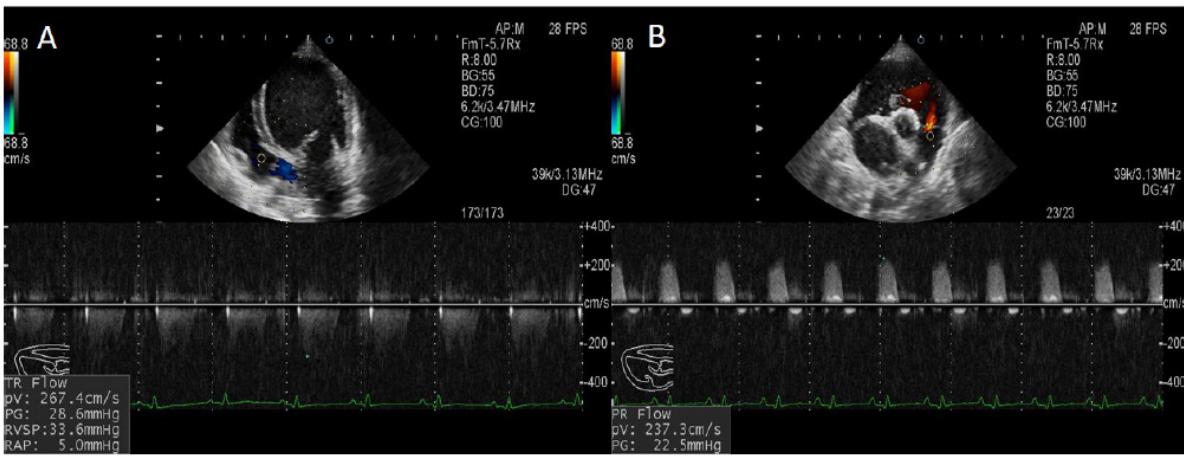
Continuous wave Doppler echocardiogram. Note tricuspid regurgitation (3.39 m/s) on the left long-axis of a four-chamber view (A) and pulmonary regurgitation (2.37 m/s) on the left short axis view (B).
